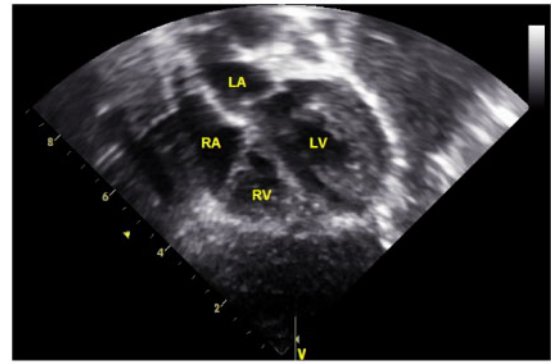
Case 1: cardiac mass on echocardiogram at 45 days of life measuring  $10 \times 21$  mm.
